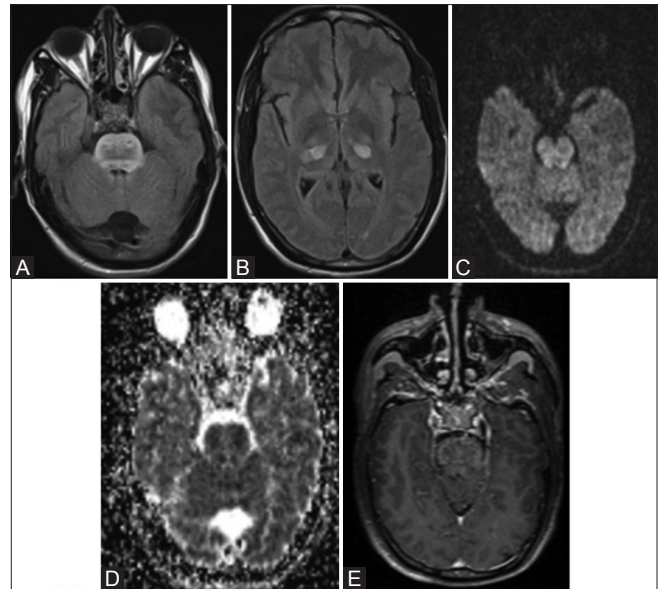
(A-E): Axial FLAIR images show bilateral symmetrical hyperintensities in thalami and pons (A and B). DWI and ADC images show restriction on diffusion in pons (C and D). Post contrast image shows meningeal enhancement along the surface of pons (E)
